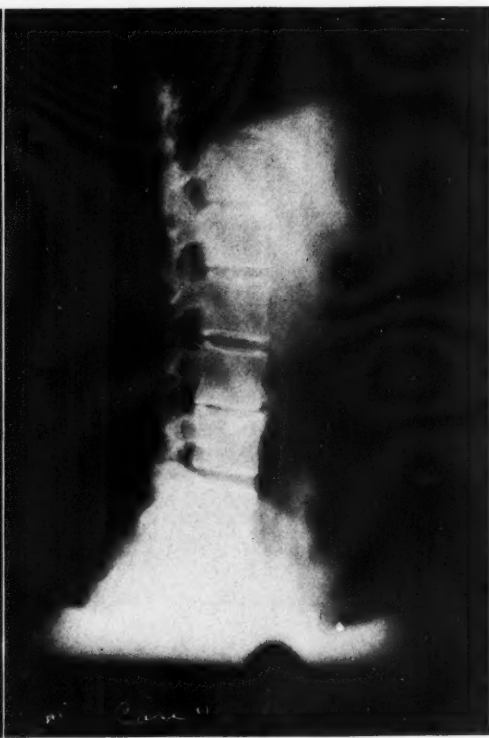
Lateral roentgenogram of Case 2.
